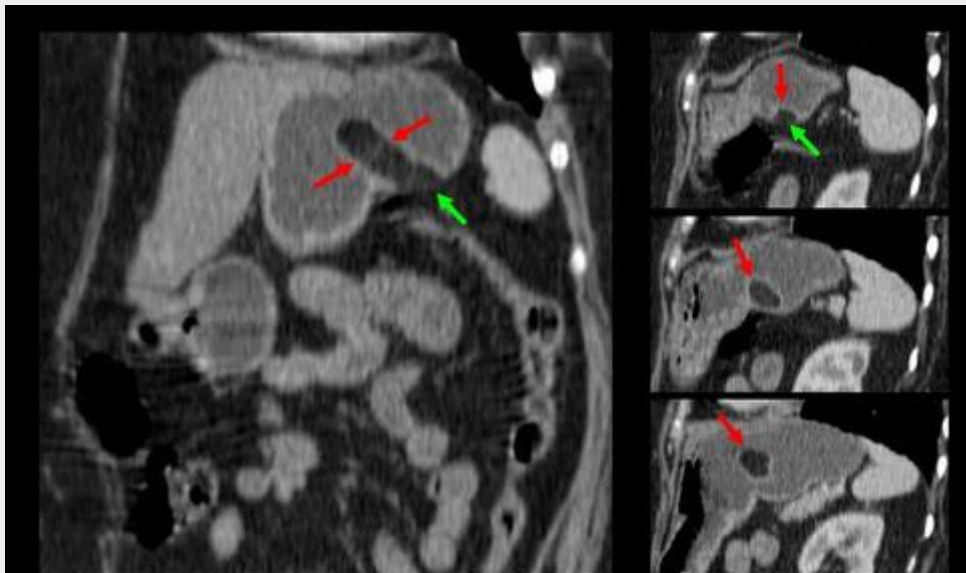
Lipoma (→). Post-contrast CT, coronal (*left*) and sagittal reformations (*right*). Note how the normal enhancing submucosal layers of the stomach's wall are interrupted by the fat-attenuation tumor, at its area of implantation (→). Note also the enhancing mucosa overlying it.
